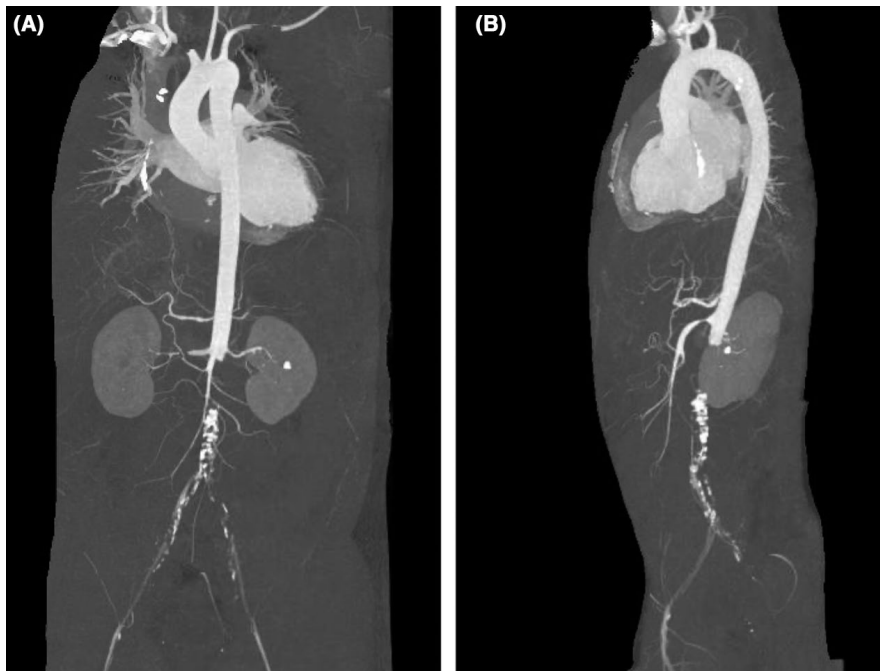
MIP (Maximum Intensity Projection) of Contrast Abdominal CT: Coronal (A) and Sagittal (B) view images show the extent of non-opacified infra-renal abdominal aorta to the bifurcation level and extensive atherosclerotic changes with narrowing of proximal SMA (superior mesenteric artery). Left kidney stone is also noted
